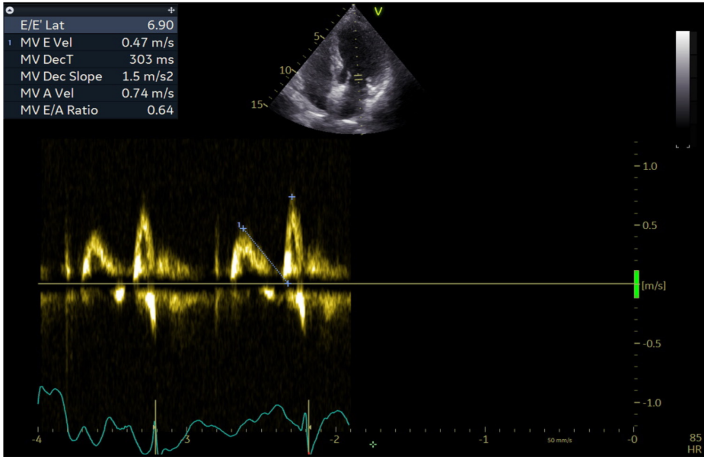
Pulsed-wave Doppler spectra on the tips of the mitral valve in apical 4 chambers view to calculate the A and E waves
